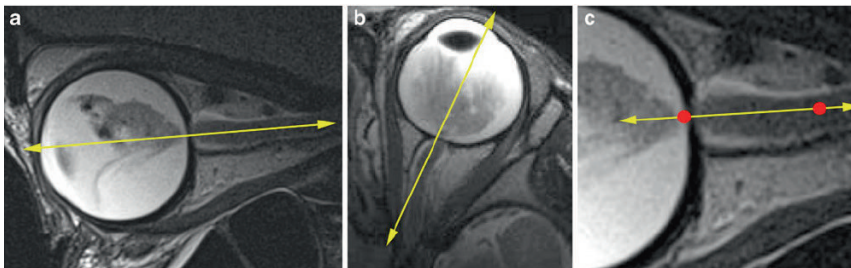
Recommended slice positions. One T2-weighted section in the sagittal oblique plane and one in the transaxial plane should be precisely aligned at the middle of the optic disk and the distal (at least 1 cm) end of the optic nerve. a Correct alignment of transaxial sections. b Correct alignment of sagittal oblique sections. c Detailed view of the distal optic nerve (line segment: imaging axis; distal 1 cm of the optic nerve between red dots)
